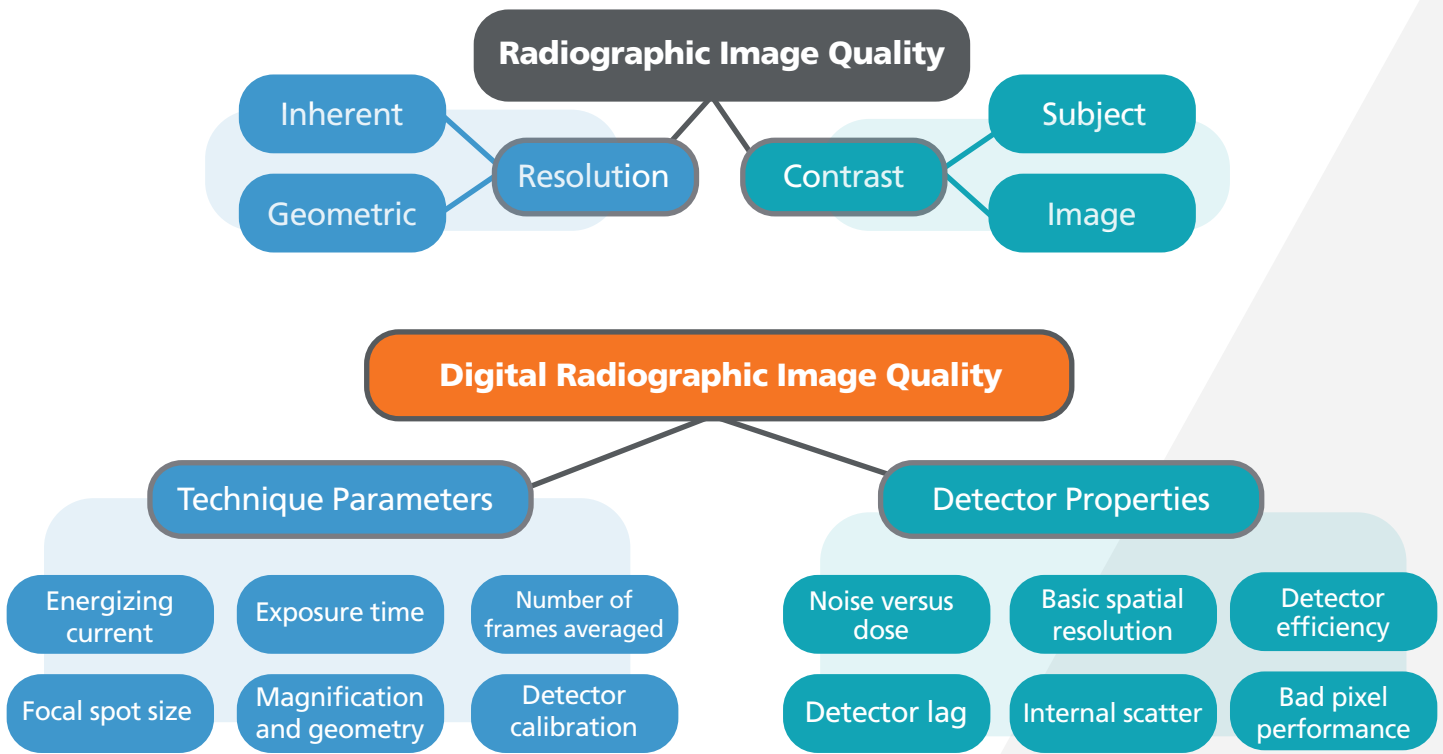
Factors that affect radiographic image quality, from ASNT Nondestructive Testing Handbook: Volume 3, Radiographic Testing 4th Edition [2]
